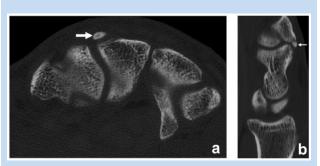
(a) Axial and (b) sagittal reformatted computed tomography images demonstrating a small os styloideum (arrow) in a 25-year-old National Hockey League player who underwent evaluation for a scaphoid fracture.
